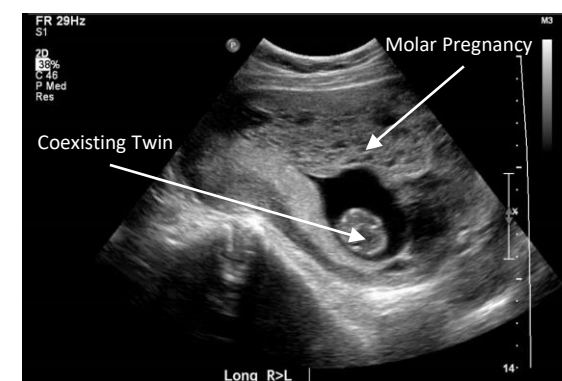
Ultrasound at 11 weeks: molar pregnancy being mistaken for a sub-chorionic haematoma
